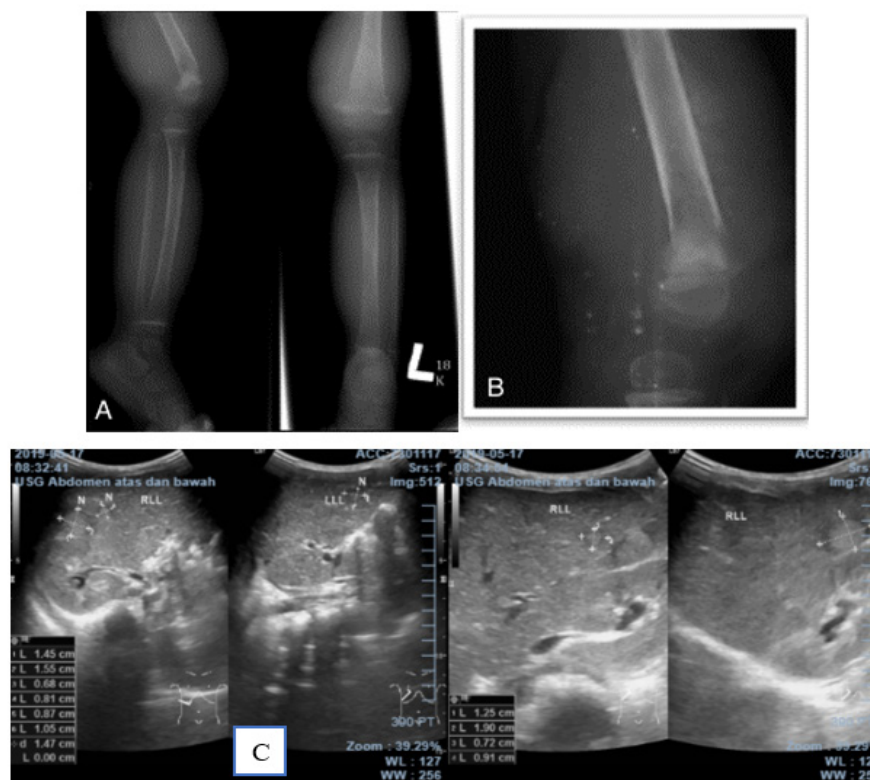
(A) Cortical destruction was observed on the distal femoral and proximal tibial bones of the left leg. In addition, an interrupted periosteal reaction and diminished trabeculation were seen on the AP and lateral projections of the radiograph. (B) The distal femoral bone showed an interrupted periosteal reaction. (C) A liver ultrasound image revealed numerous hyperechoic nodules on both lobes of the liver.
